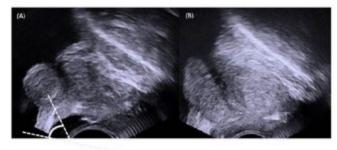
The measurements of prostatic urethral angle. (A) The PUA was defined as the angle formed by both proximal and distal prostatic urethra on the sagittal plane image. (B) The example of PUA in transrectal ultrasonography.
